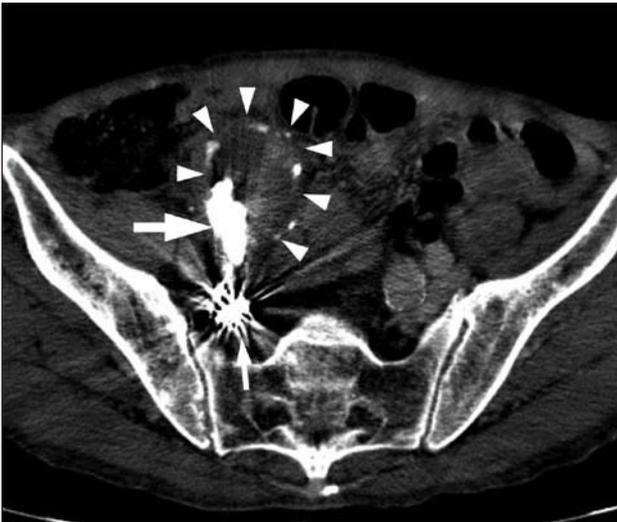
Computed tomography angiogram showing glue cast (big arrow) occluding the site of the leakage at the inferior part of the right common iliac artery aneurysm. The right common iliac artery aneurysm is largely thrombosed (arrowheads). Coils (small arrow) indicate the site of the previous internal iliac artery embolisation.
